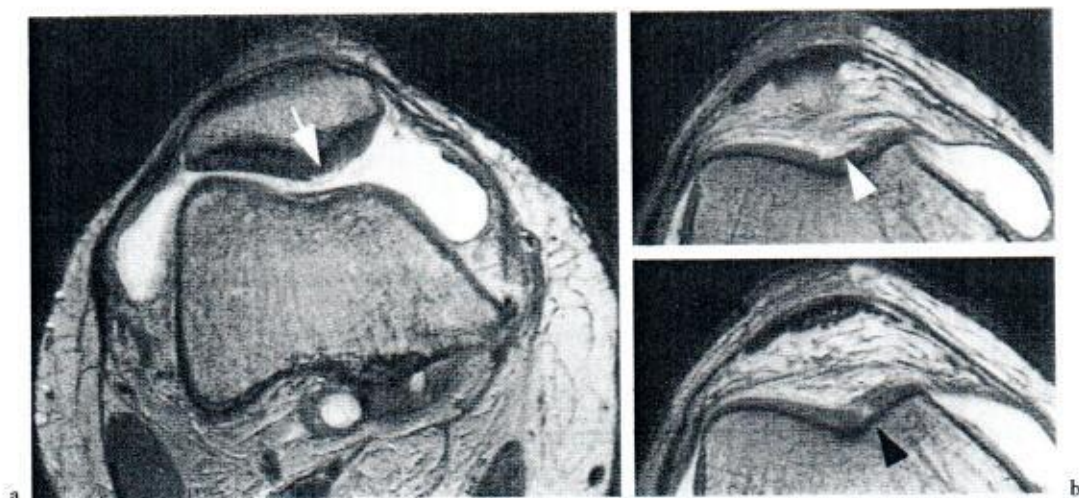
Transaxial MR images of the knee of the same patient as in Fig. 13.33. In the patella (*arrow*) and the femoral condyle (*white arrowhead*) there are superficial cartilage defects and in another section fissuring of the cartilage to the subchondral bone (*black arrowhead*). Even small cartilaginous lesion can be demonstrated with this proton fat-saturated sequence
